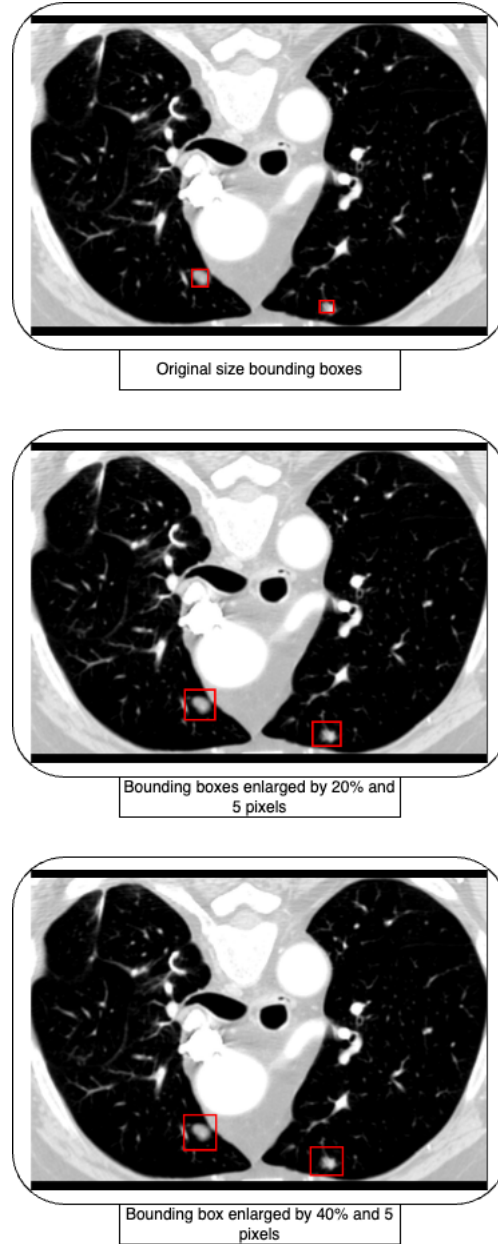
Visualization of bounding box expansion and padding effects on CT images. Top: Bounding box of normal size. Middle: Bounding box enlarged by 20% and 5 pixels. Bottom: Bounding box enlarged by 40% and 5 pixels. The red boxes highlight the expanded regions around the nodules, demonstrating how different configurations influence contextual information available to the model.
